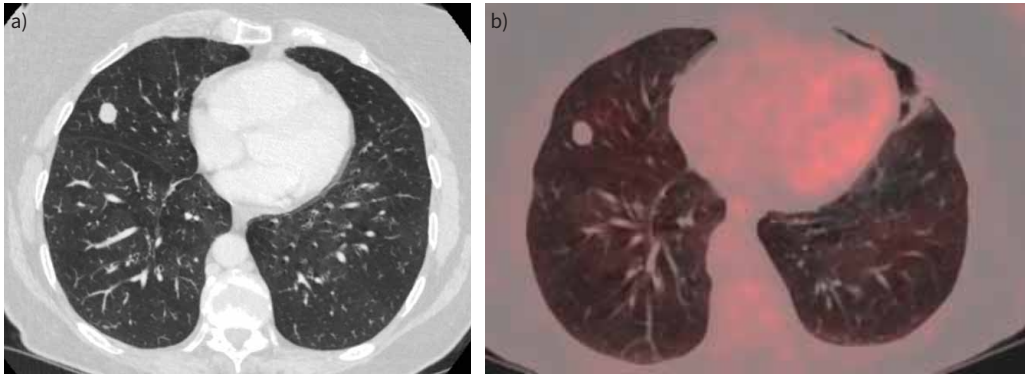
Slices from a) high-resolution computed tomography of the thorax and b) positron emission tomography scan.
